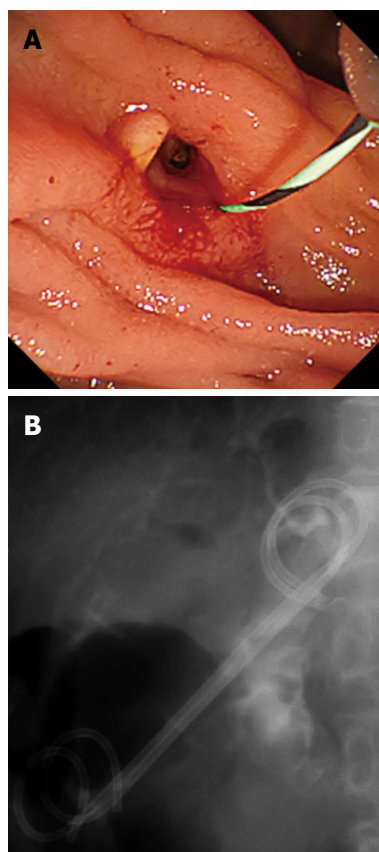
Images of biliary cannulation and plastic stent placement via an endoscopic ultrasound-guided choledochoduodenostomy fistula. A: A matured fistula was created where the removed metallic stent was placed. The common bile duct (CBD) was cannulated via the EUS-CDS fistula using an ERCP catheter and a guidewire was inserted; B: Two 7-Fr double pigtail plastic stents were placed into the CBD via the EUS-CDS fistula. EUS-CDS: Endoscopic ultrasound-guided choledochoduodenostomy; ERCP: Endoscopic retrograde cholangiopancreatography.
